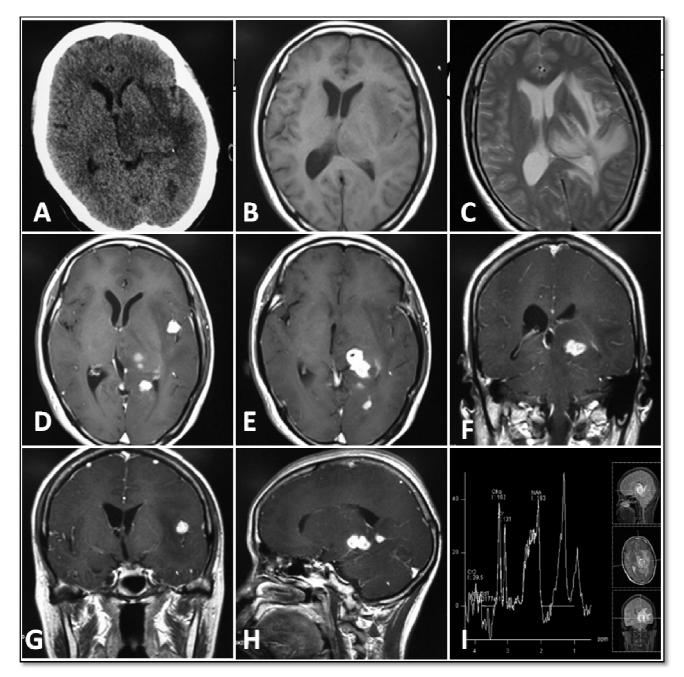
The CT and MR images of this patient. A: cranial CT scan showed mass effect on the left side of the brain with finger-like edema. B-H: Gadolium enhancement MR showed homogeneous enhanced lesions in the left temporal and insular lobe, thalamus and basal ganglia. I: MRS showed a relative normal ratio of Cho/NAA (<1), lactic peak was visible indicating anaerobicmetabolism inside the lesion.
